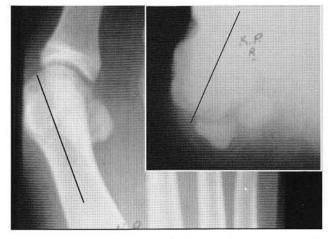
AP radiograph showing tibial sesamoid in position 7. Axial xray of same foot reveals sesamoid in position 3+. Note the position of the cristae in relation to the bisection of the 1st metatarsal on the axial position.
